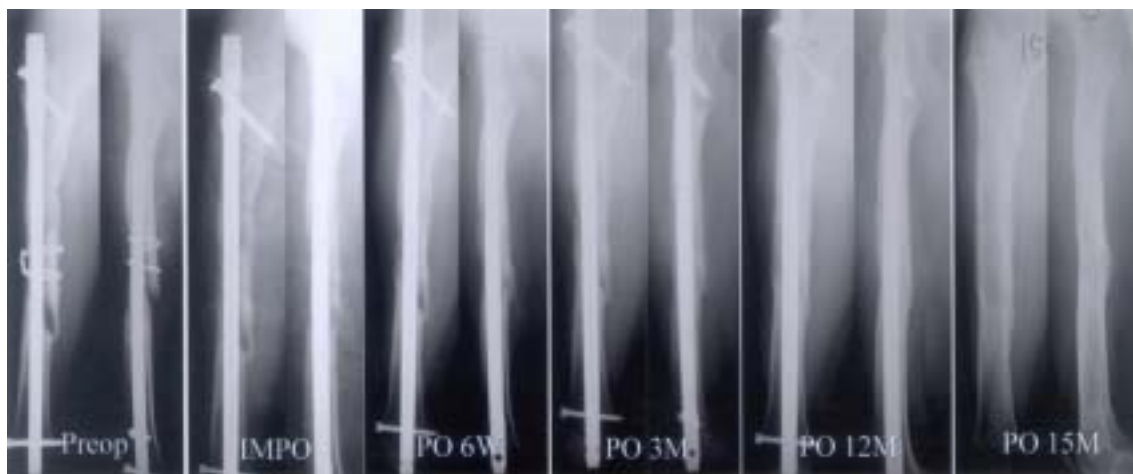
This 22 year-old female patient had undergone IM nailing for the type IIIA open fracture of femur mid-shaft in our hospital, which resulted in infectious osteomyelitis with draining sinus. Wound culture was negative and initial CRP of 30 mg/dL was controlled to 2.1 mg/dL before surgery. At postoperative 9 months, she underwent vancomycin-cement coated unreamed intramedullary nailing, whose femur gained radiographically complete bony union at 12 months, and whose implant was removed at 15 months postoperatively. We allowed partial weight bearing at postoperative 6 weeks, full weight bearing at postoperative 3 months.
